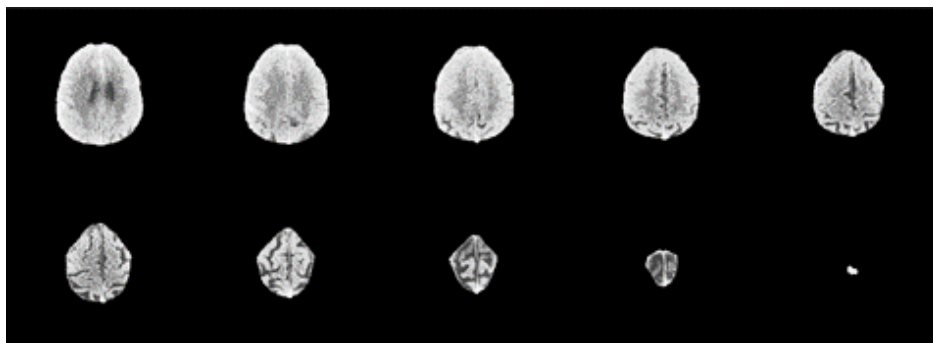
A representative CT scan showcasing the sulci region delineated within the specified analysis area
